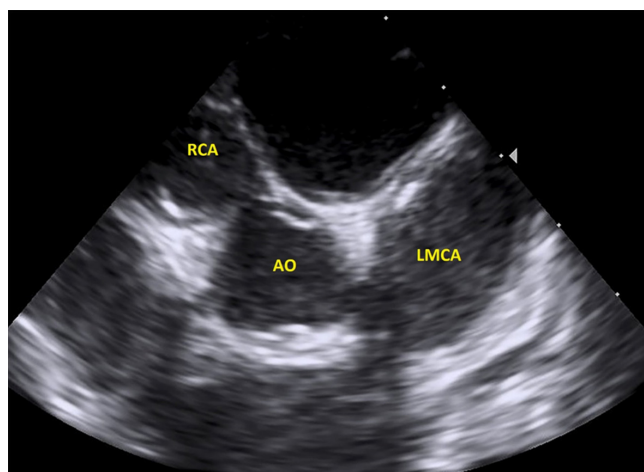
Huge aneurysm without thrombosis in the images of the Right coronary artery and left main coronary artery in short axis view with transthoracic echocardiography.
